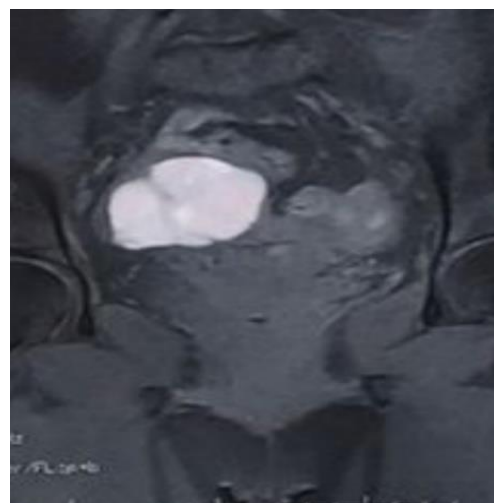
(MRI) revealed hyperintensity on T2-weighted imaging
